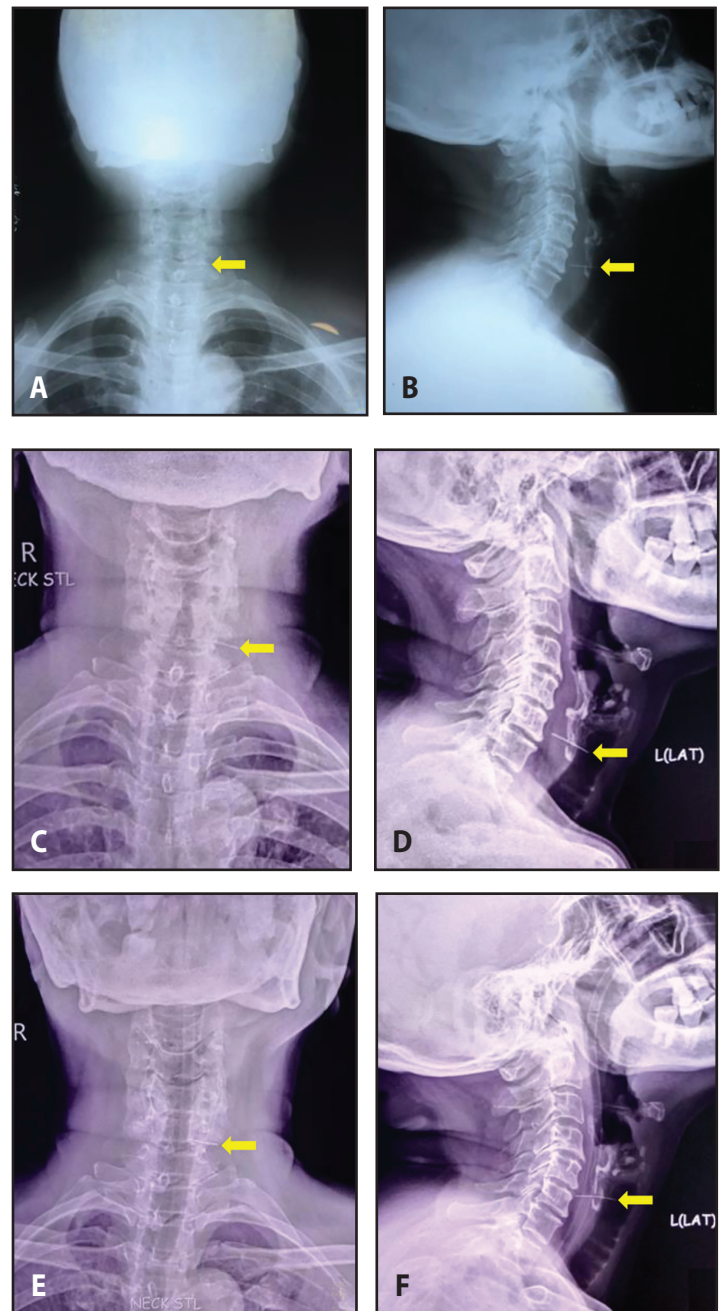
Serial soft tissue neck radiographs. A. antero-posterior, and B. lateral, taken two days post-ingestion; C. antero-posterior and D. lateral, obtained on the day of admission; E. antero-posterior, and F. lateral, taken on the fourth hospital day. Note the persistent metallic spindle-shaped foreign body (arrows) lodged in the prevertebral region at the level of the left C6 vertebra
